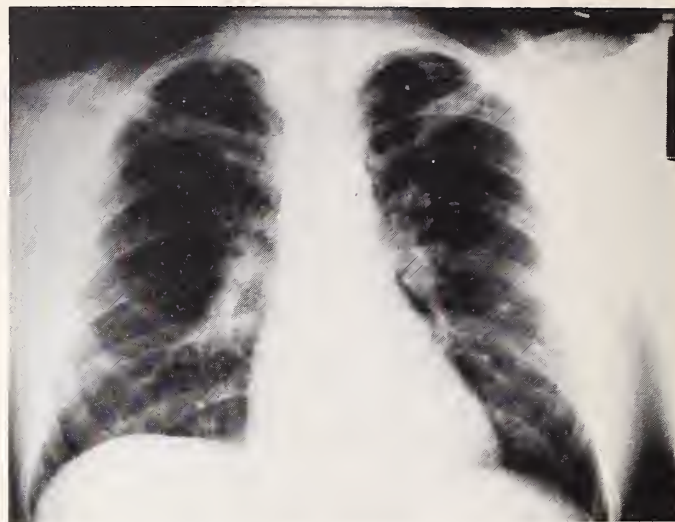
Chest x-ray at discharge after treatment with amphotericin B showing marked resolution.
